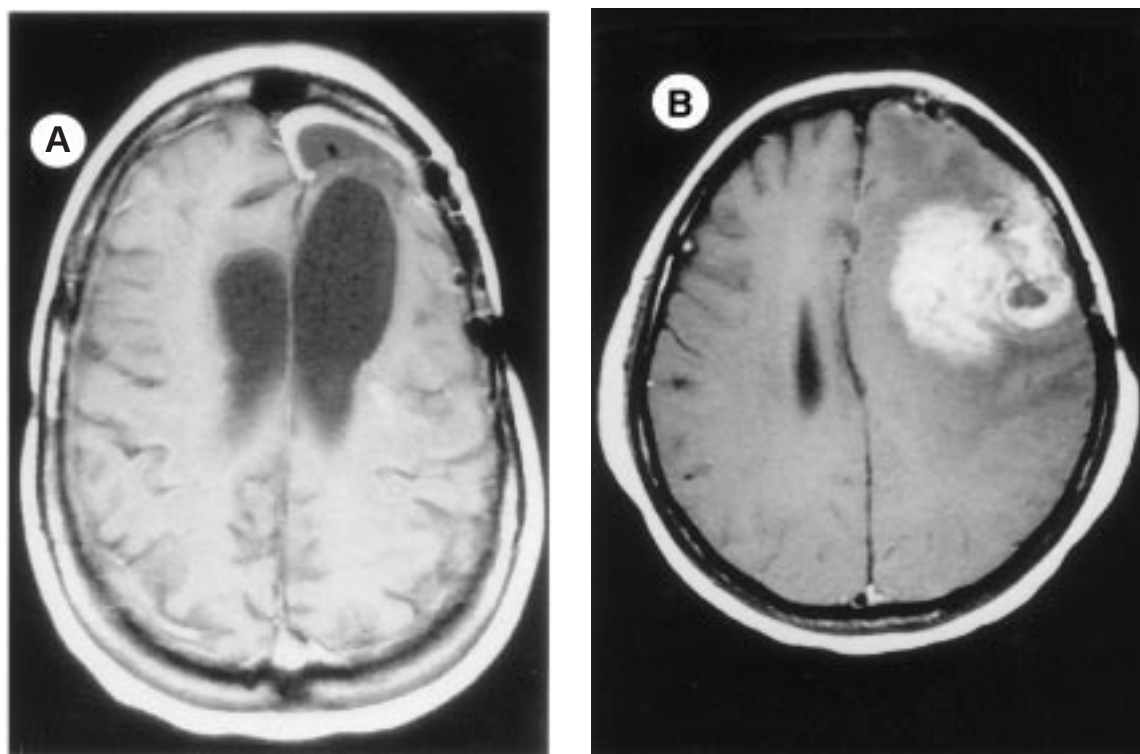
MR imaging studies of asymptomatic hydrocephalus (A) and transient cerebral swelling (B) at the completion of TIL immunotherapy.
